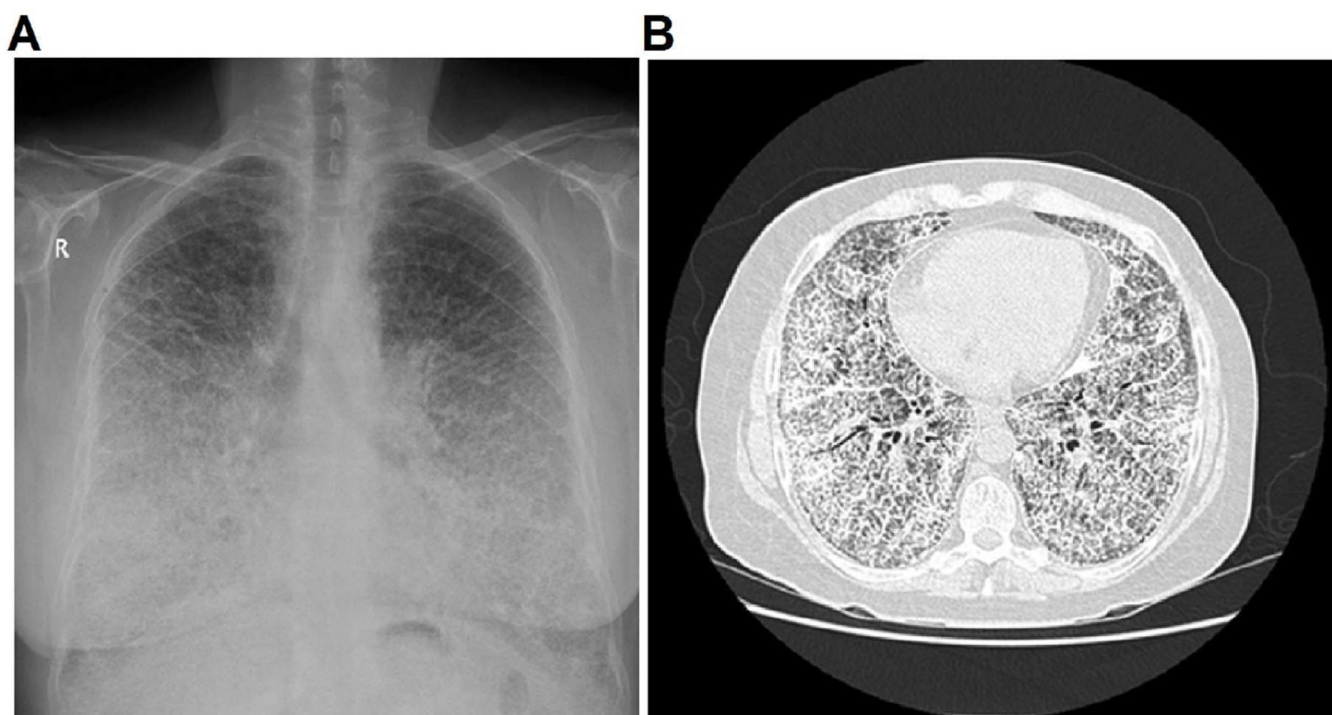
Chest radiograph (A) and High-resolution computed tomography findings (B) of a 59-year-old Middle Eastern female with a history of pulmonary alveolar microlithiasis, showing diffuse opacification in both lung with hyper dense micronodular, called "sand-storm appearance" From Gupta, N. & McCormack, F.X. Pulmonary alveolar microlithiasis. *Am J Respir Crit Care Med* 2013;188(7):e11–12; with permission.
